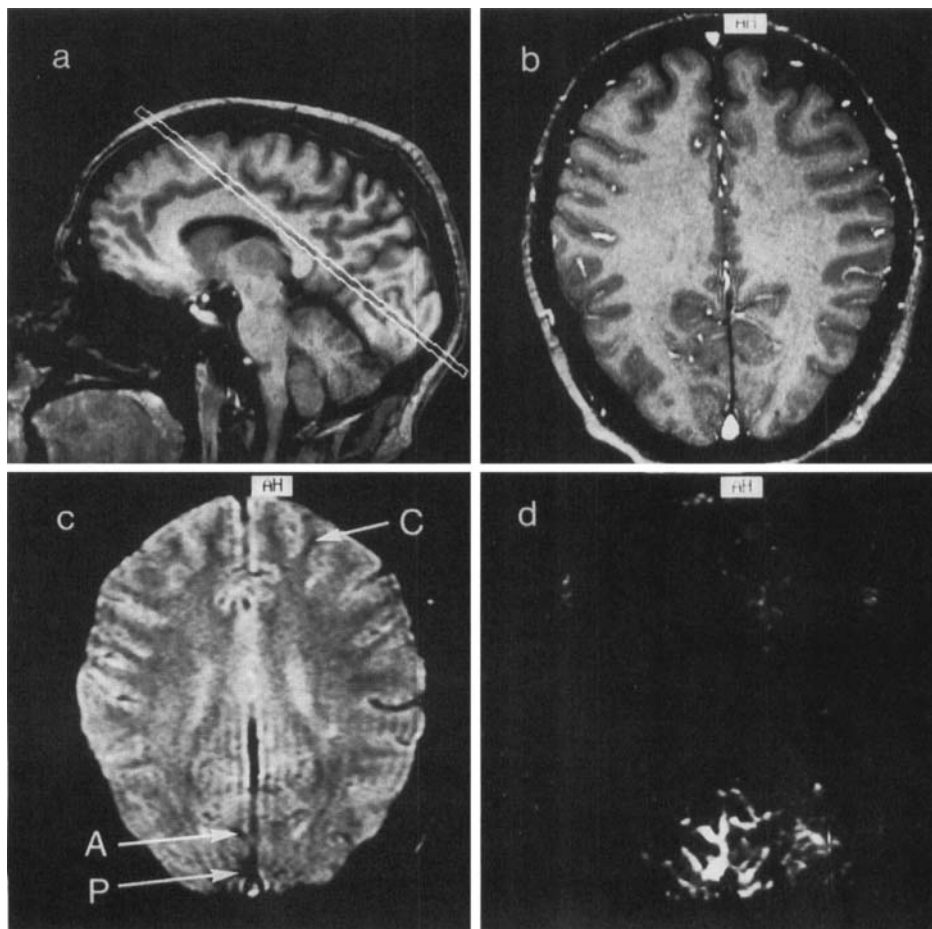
(a) Plane orientation for activation studies of visual cortex, (b) corresponding flow-sensitized anatomic image, (c) CBO-sensitive image (RF-spoiled FLASH, $TR/TE = 100/30$ ms, flip angle 20° , matrix 128×256 , FOV 200 mm, slice thickness 4 mm) from the CINE MRI data set, and (d) CINE MRI difference map obtained by subtracting an averaged baseline image from an averaged image acquired during visual stimulation. The arrows indicate locations of the control (C), anterior (A), and posterior (P) ROIs used in Figs. 2 and 4, respectively.
